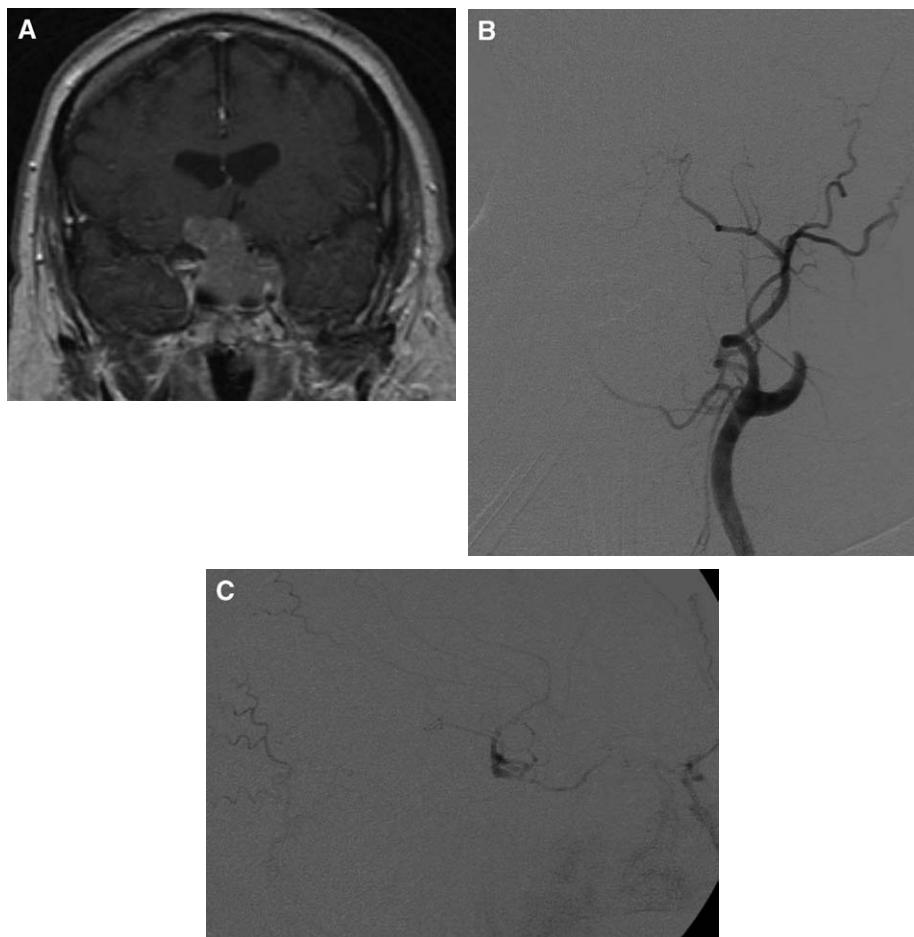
(A) Intraoperative bleeding encountered during transphenoidal hypophysectomy for a large pituitary tumor seen on MRI. After packing, angiography revealed carotid occlusion (B) and poor circle of Willis collaterals on the intracranial view (C).
